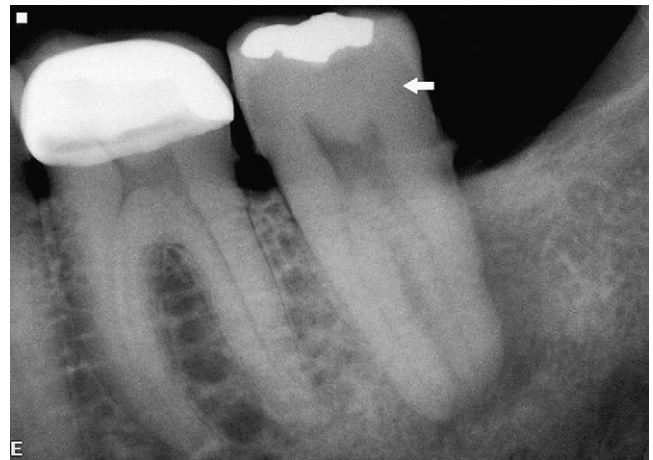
Mandibular second molar (arrow) with a nonvital pulp, periapical bone resorption, and a minimal restoration.
